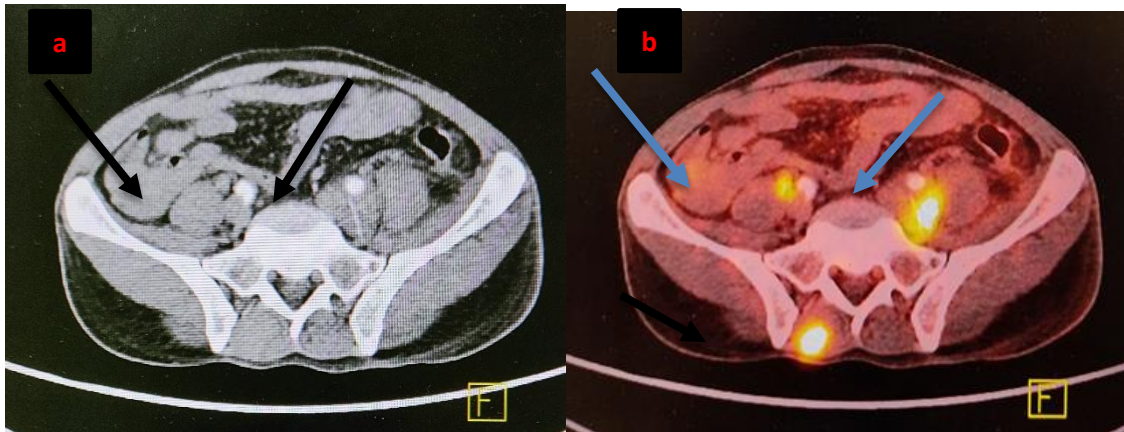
(a) Axial CT scan shows bilateral enlarged common iliac nodes (black arrows); nodal involvement was positive by CT criteria, however paraspinal muscle involvement was not detected; (b) Axial fused PET/CT image shows increased FDG activity in the right paraspinal muscles in the lumbosacral region (black arrows) and common iliac nodes (blue arrows); nodal as well as muscle was considered involved by PET/CT criteria.
